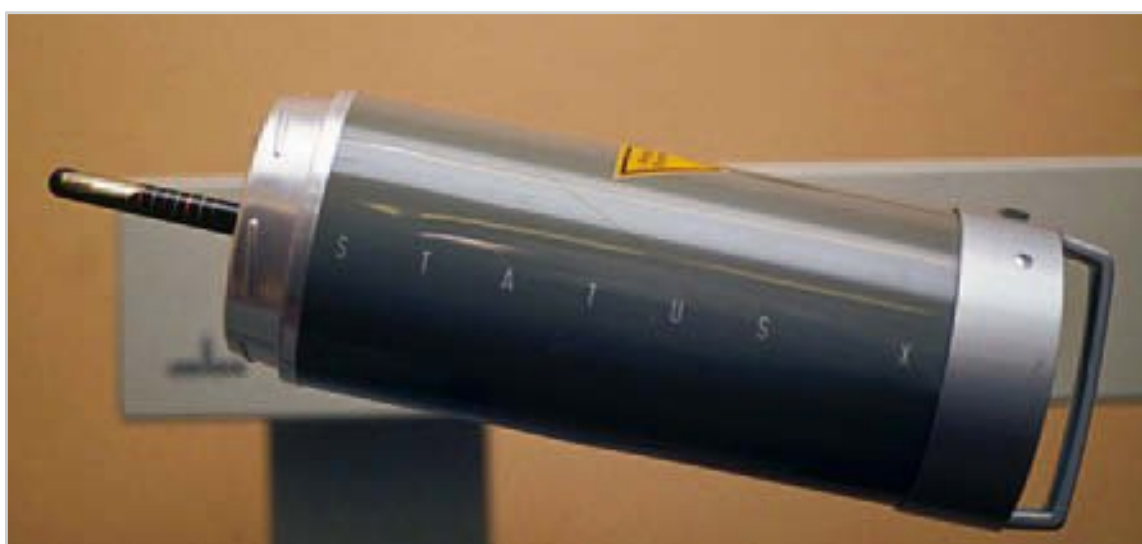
Status-X panoramic X-ray apparatus by Siemens.
